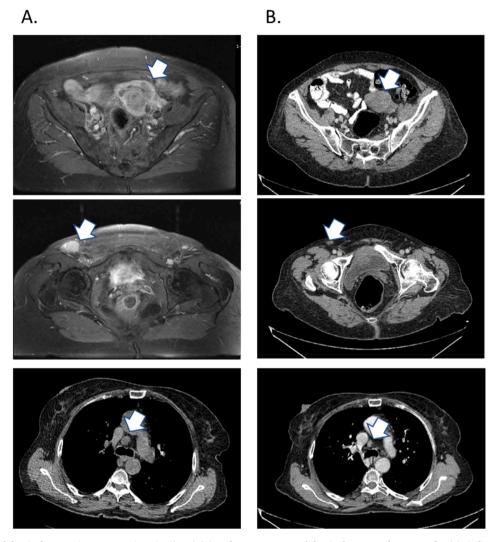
Pre-treatment abdominal magnetic resonance imaging (MRI) (A) and post-treatment abdominal computed tomography (B), indicative of partial response.
